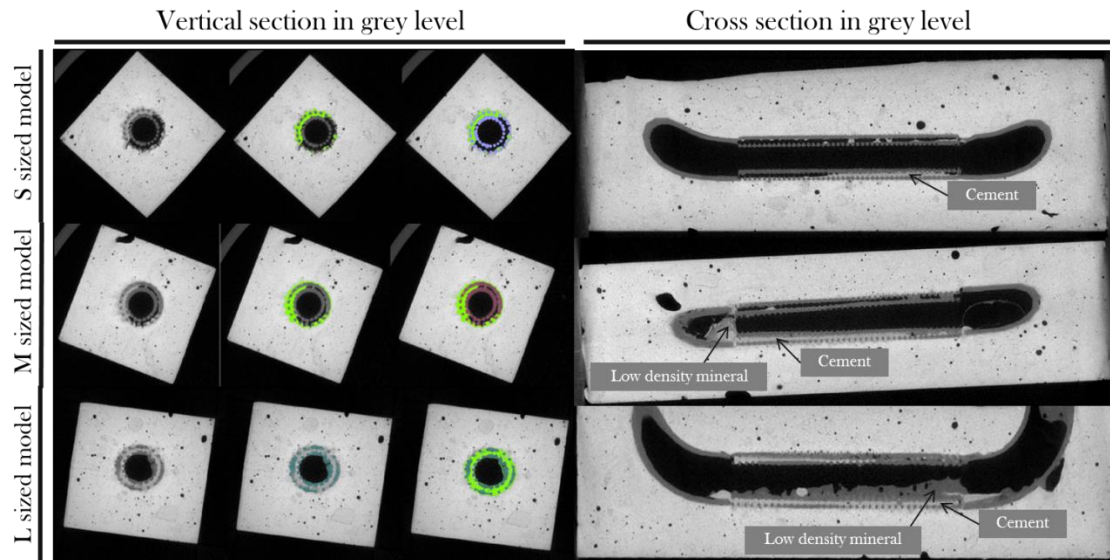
CT gray level images of cement matrix incorporating with L/M/S model, where the fluorescent green coloured part represents cement in the model; violet coloured part represents PLA structure of S sized model; pink coloured part represents PLA structure of M sized model; cyan coloured part represents PLA structure of L sized model
